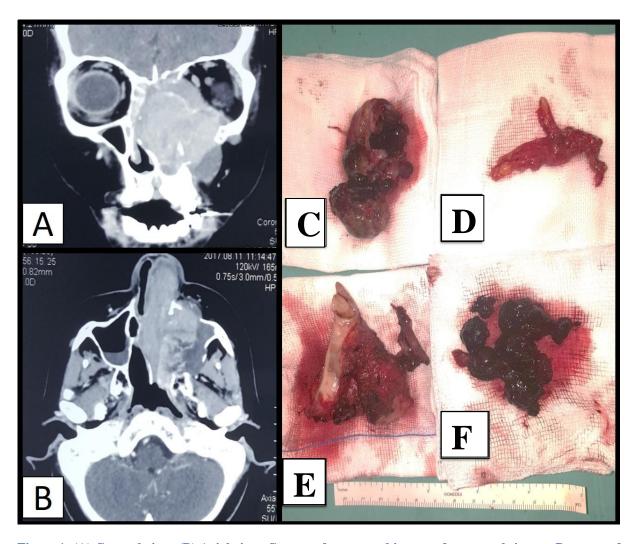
(A) Coronal view; (B) Axial view: Computed tomographic scan of paranasal sinuses. Presence of voluminous mass from left maxillary antrum with erosion of anterior wall of maxillary sinus (axial view). The mass pushed the septum to the right side and appeared to involve left orbit (coronal view). Intraoperative findings showed (C) Intranasal mass; (D) Buccal mucosa; (E) Left maxillary bone with mass; (F) Intramaxillary mass; there was black pigmented mass in the maxillary sinus (F) and nasal cavity (C) with erosion of anterior wall of maxillary bone (E).
